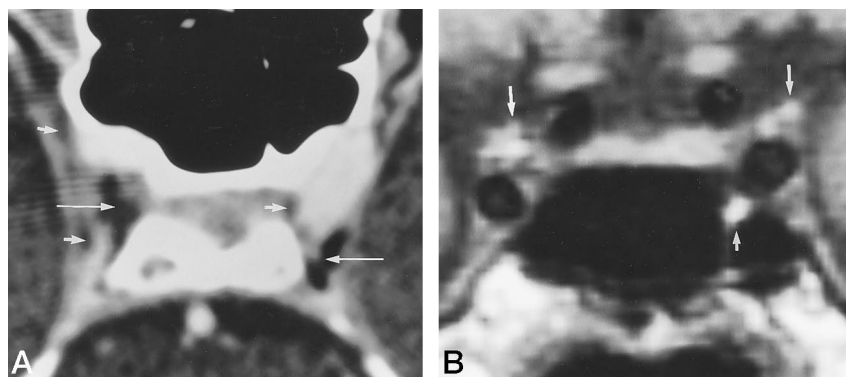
A, Axial contrast-enhanced CT scan in a healthy control subject shows an 8-mm filling defect of fat density within middle and posterior compartment of right cavernous sinus (*long arrows*) and smaller filling defect within left posterior cavernous sinus (*long arrows*). Additional small filling defects of fat density/signal intensity are present in the lateral right and medial left cavernous sinus (*short arrows*).
